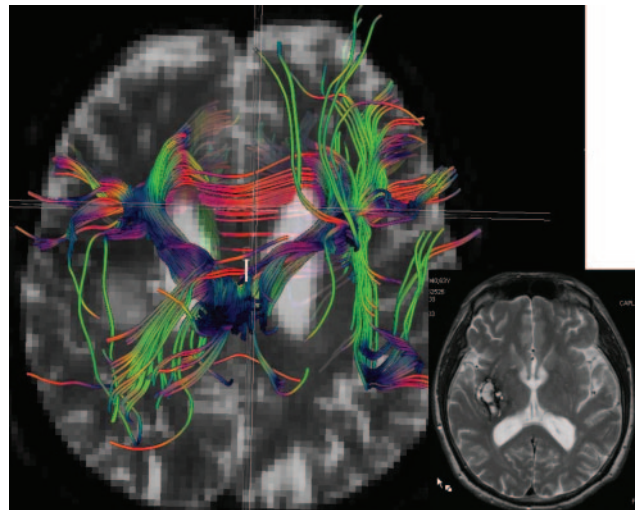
Diffusion tensor tractography demonstrating severe asymmetry after hemorrhagic stroke. Inset shows a T2-weighted image five months after ictus demonstrating residual hemorrhage in the posterior right basal ganglia. Tractography using symmetrical seed-points in the brainstem demonstrates marked reduction of fiber tracts in the affected (right) hemisphere compared to the left. Directional color scheme: red indicates right-left; green, anterior-posterior; blue, superior-inferior. Diffusion tractography may be able to identify white matter tracts and changes in them related to ICH and recovery. (Image courtesy of A. Gregory Sorensen, MD, Massachusetts General Hospital, HST AA Martinos Center.)
